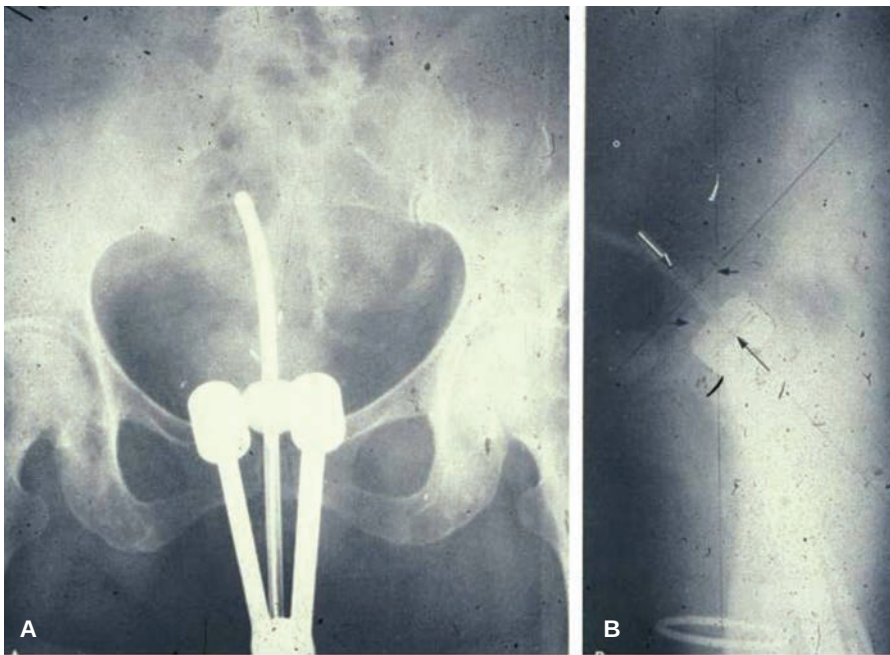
Ideal position of tandem and ovoid applicator on an AP radiograph A: and a lateral radiograph B: Note the metallic seeds inserted into the cervix.
